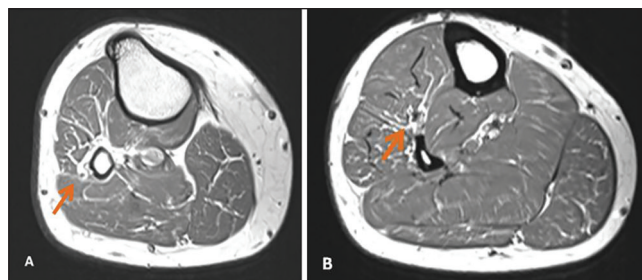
MRI of right leg (axial section) showing normal intensity in (a) common peroneal nerve and (b) deep peroneal nerve. MRI = Magnetic resonance imaging
